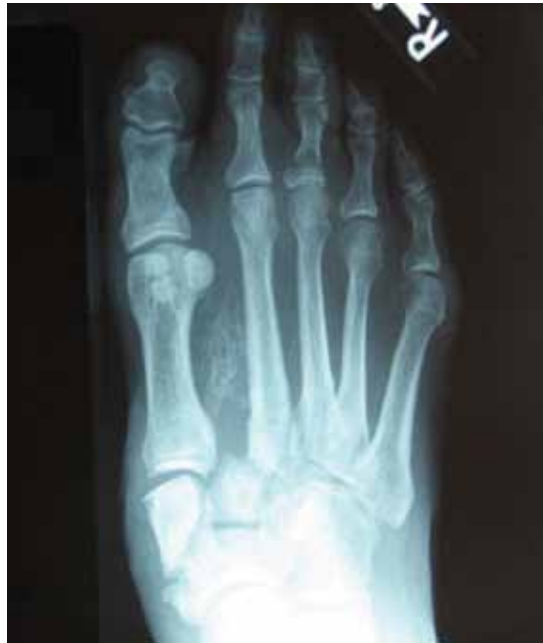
In this radiograph taken 3 to 4 months after the initial presentation, Charcot neuroarthropathy has progressed to stage 2 after delayed immobilization.
